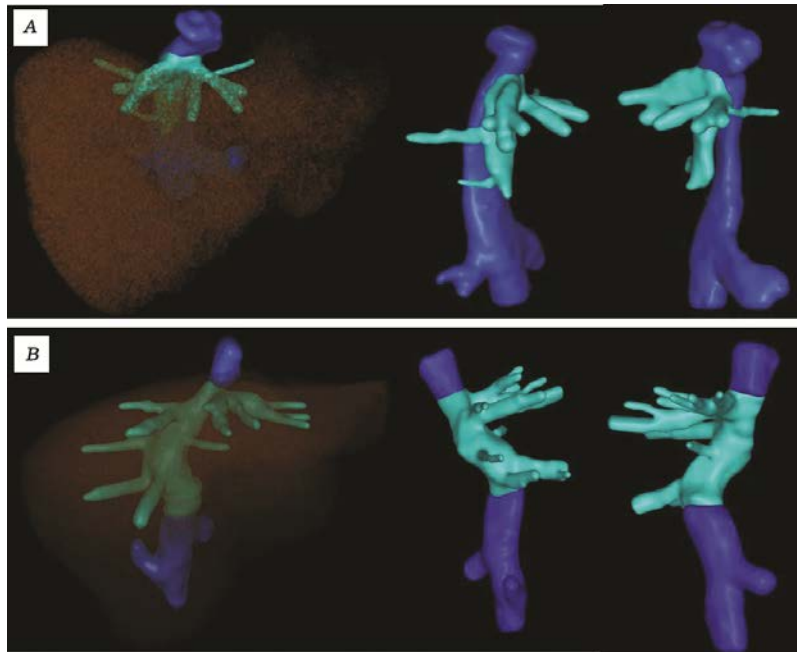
Computed tomography imaging (3D reconstruction) of the caval-caval anastomosis at early stage after transplantation: (A) modified cavocavostomy – option 1; (B) classic technique: inferior vena cava of the recipient in blue color; the donor's inferior vena cava fragment in light-blue
